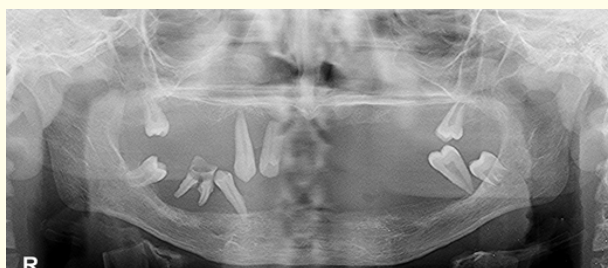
Orthopantomogram at the age of 15 years showing severe periodontal destruction of the remaining teeth.
